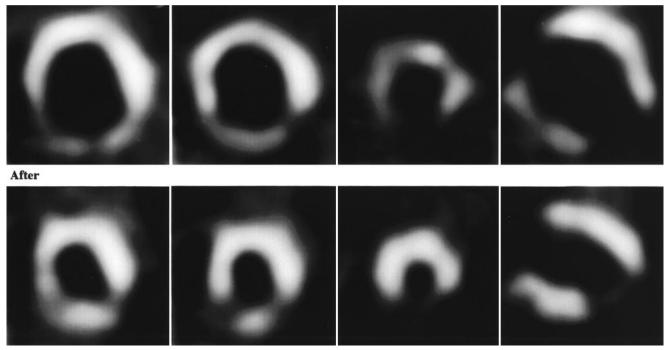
Representative SPECT <sup>123</sup>I-MIBG images before and after spironolactone treatment in dilated cardiomyopathy.
